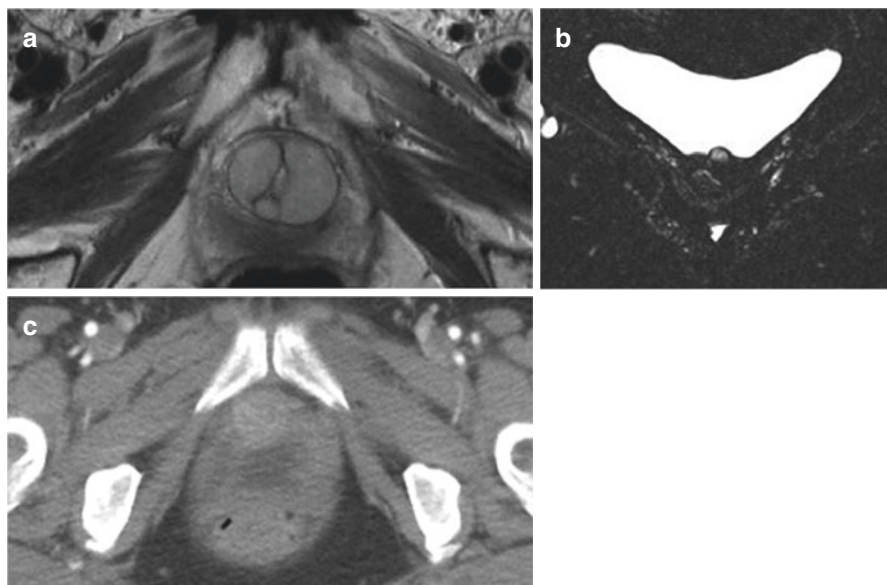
UBAs identified on various imaging modalities can be easily misinterpreted. (a) Axial magnetic resonance imaging of collagen bulking agent which was correctly interpreted on radiographic read. (b) Coronal magnetic resonance imaging of collagen bulking agent which was radiographically interpreted as “possible urethral diverticulum.” (c) Axial computerized tomography imaging of Macropastique™ bulking agent which was radiographically interpreted as “increased attenuation of soft tissue”. (Images a-c courtesy of Anne Cameron MD)
